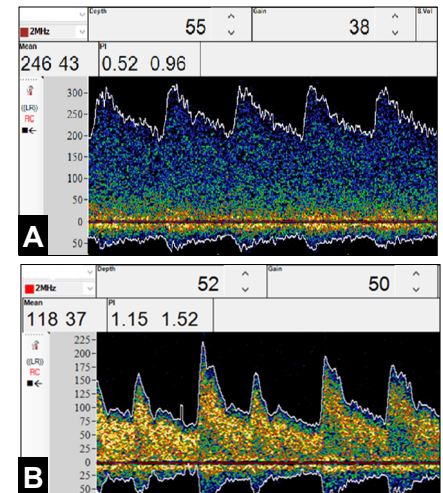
L-MCA transcranial Doppler, showing mean flow velocities before (A) and after (B) intrathecal Nitroprusside infusion.
